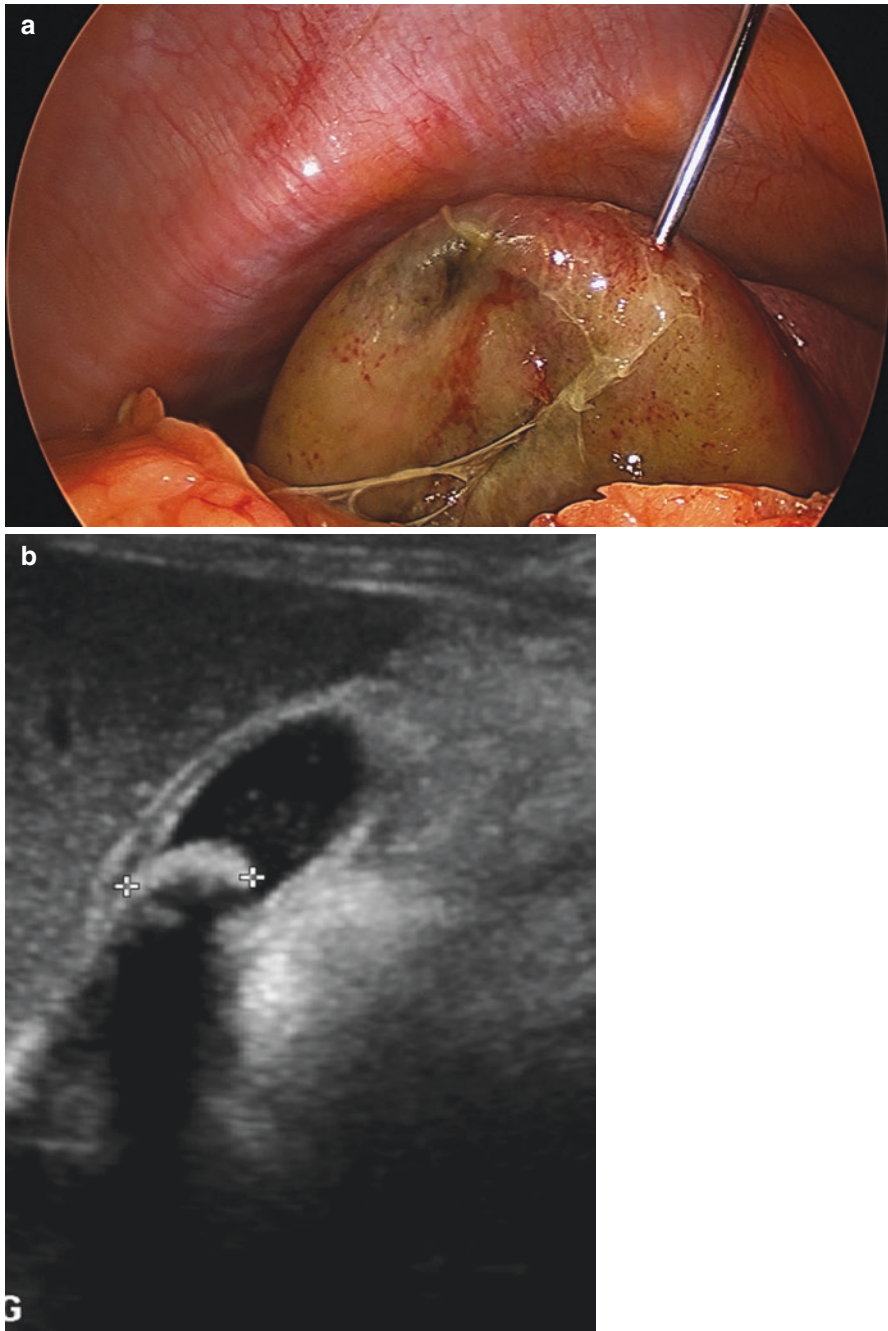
A 52-year-old man who presented with 48 h of prolonged biliary pain with right upper quadrant tenderness and evidence of sepsis with fever, tachycardia and elevated white cell count (22,000). An urgent LC was performed. (a) The gallbladder was clearly gangrenous and was very distended and tense, so it was drained with a Concord needle. (b) The ultrasound on this confirmed a stone impacted in the neck of the gallbladder with a thickened gallbladder wall associated with pericystic fluid. However, there are no ultrasound features that predicted the gangrenous cholecystitis
